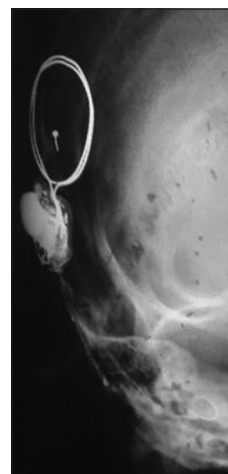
X-ray of the skull lateral view showing displacement of magnet from its silicon socket inferiorly
